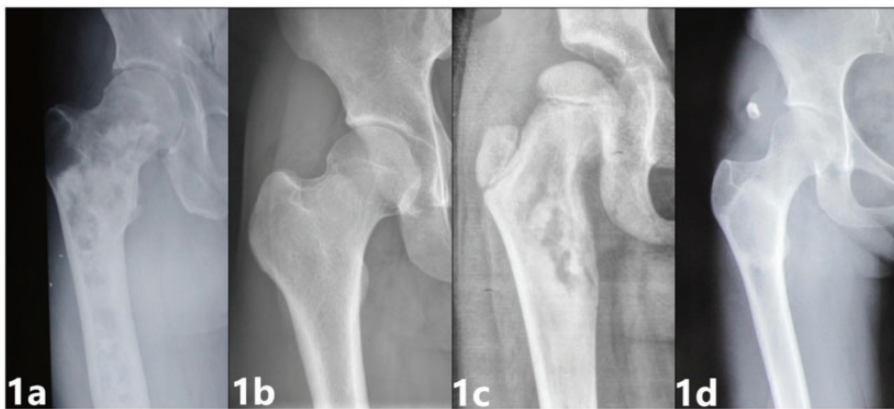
Anatomic classification of fibrous dysplasia of the proximal femur based on findings on radiographs. (a) Type A: the lesion covers the entire proximal femur. (b) Type B: the lesion only involves the femoral neck. (c) Type C: the lesion involves the femoral neck and intertrochanteric region and (d) Type D: the lesion involves only the intertrochanteric area.
